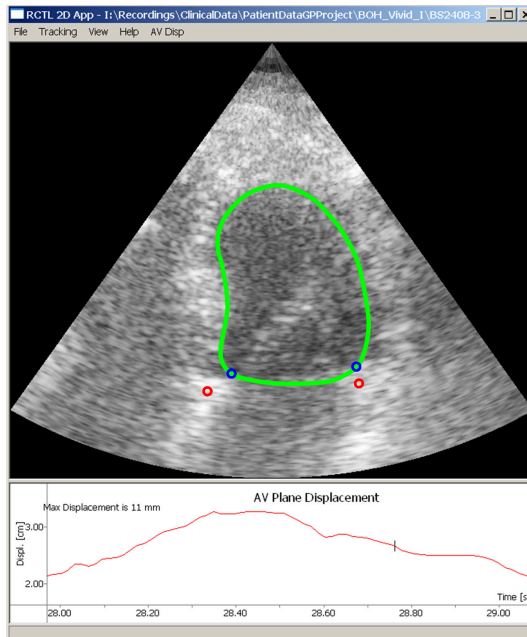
Example segmentation from a hand-carried ultrasound recording (same patient as in Fig. 4). The circles in the basal region of the model correspond to $\mathbf{p}_{i,K}$ and the ones in the myocardium corresponds to $\mathbf{x}_{i,S}$.
